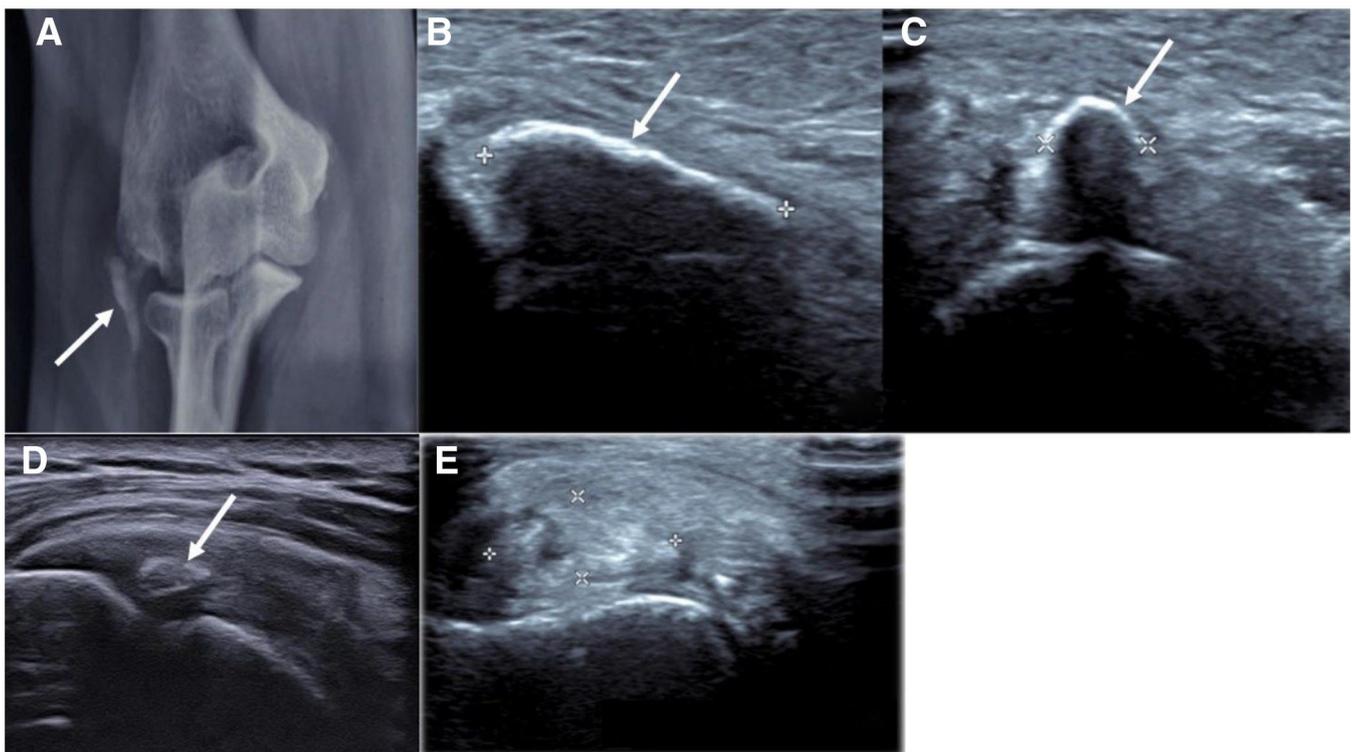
Three types of calcifications; Type 1 calcification (A, B, and C), conventional radiograph (A) shows distinct well circumscribed dense calcification (arrow), ultrasound in long axis (B) and short axis (C) showing well defined hyperechoic focus with distinct distal acoustic shadowing like a gallstone (arrow) in common extensor tendons of the elbow. Type 2 calcification (D) Ultrasound showing Type 2 calcification (arrow) in supraspinatus tendon corresponding to early resorption having faint distal acoustic shadowing. Type 3 calcification (E) grey scale ultrasound showing Type 3 calcification (calipers) corresponding to established resorptive phase showing no distal acoustic shadowing.
